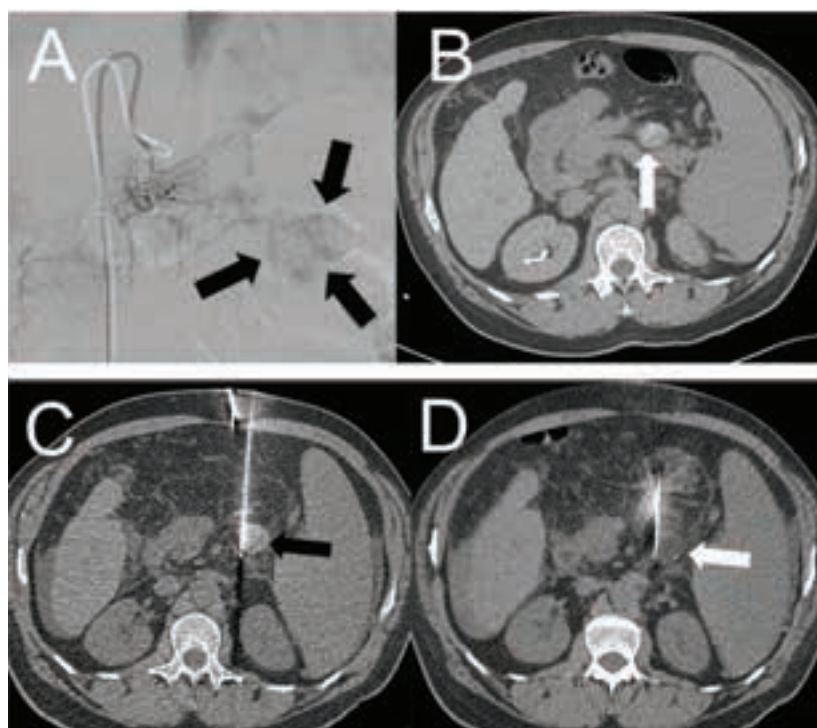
A. Digital subtraction angiography via a microcatheter within the anterior pancreaticoduodenal artery demonstrating a hypervascular mass within the pancreas (black arrow). B. A noncontrast CT performed post-embolization demonstrating radiopaque beads within the insulinoma (white arrow). C. Axial noncontrast CT image demonstrating the pancreatic mass (black arrow) with a cryoprobe along its medial border. D. Axial CT fluoroscopy image demonstrating an ice ball within the targeted insulinoma (white arrow) with cryoprobe medially.
